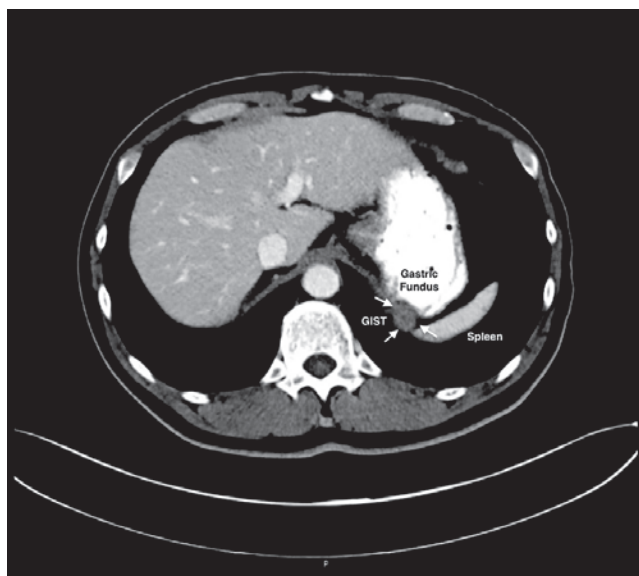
Contrast enhanced CT scan of abdomen (white arrow to the mass)
